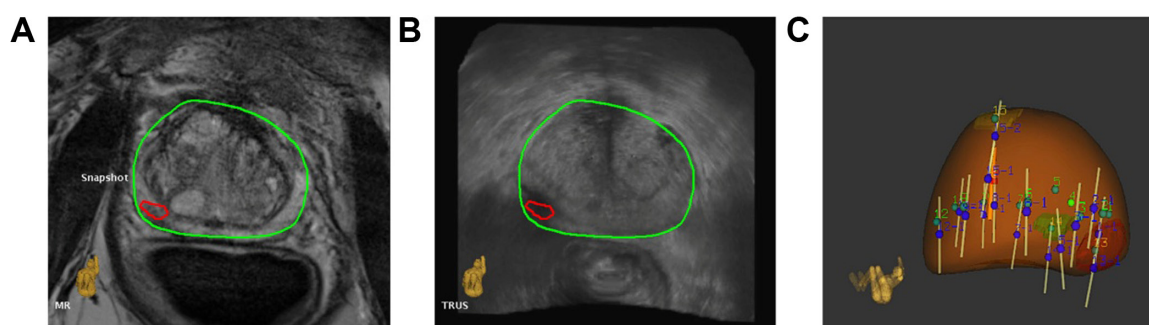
Depiction of MRI–US fusion. (A) and (B) show axial slices of fused MR and US images, respectively, with overlaid prostate contour (green) and lesion (red); (C) 3D prostate surface (brown) with archived biopsy core locations (white cylinders) after systematic and fusion biopsy.
